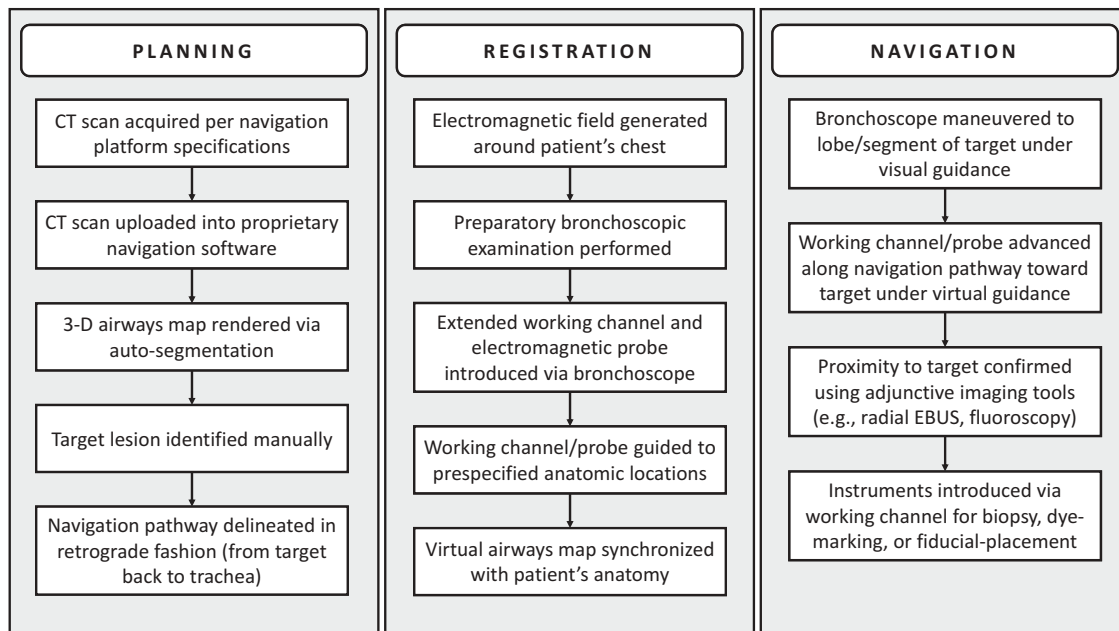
Phases of electromagnetic navigation bronchoscopy. Electromagnetic navigation bronchoscopy may be divided into three phases – planning, registration, and navigation. Despite some important differences between navigation platforms, the overarching principles are similar across the three commercially available systems. CT = computed tomography. EBUS = endobronchial ultrasound.
